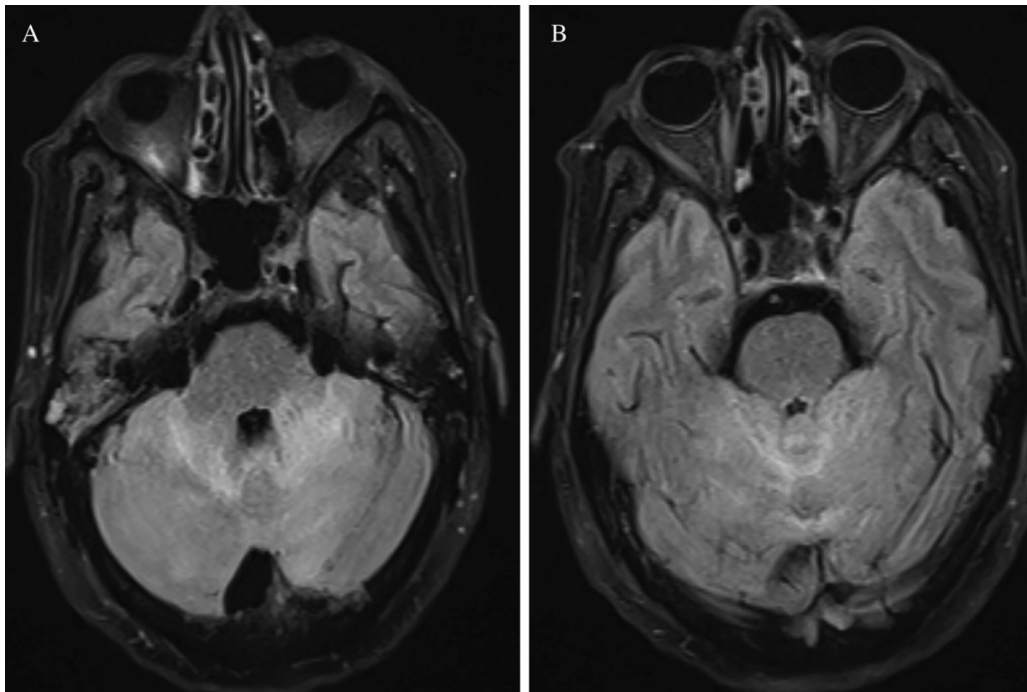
A, B) Axial FLAIR-weighted brain magnetic resonance imaging shows significant tentorial hyperintensity
